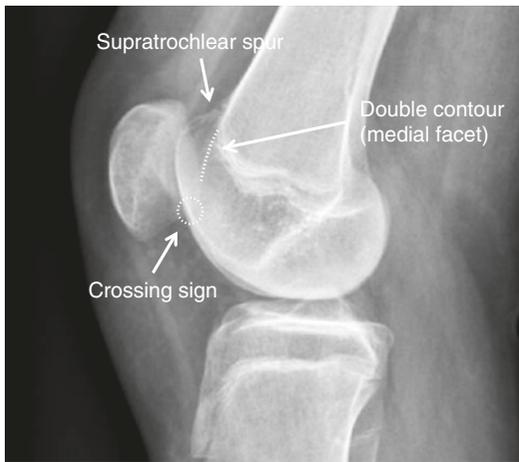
Lateral radiography of a type D trochlear dysplasia. Notice the presence of all three signs used in Dejour’s trochlear dysplasia classification: crossing sign, supratrochlear spur, and the double contour of the medial facet
